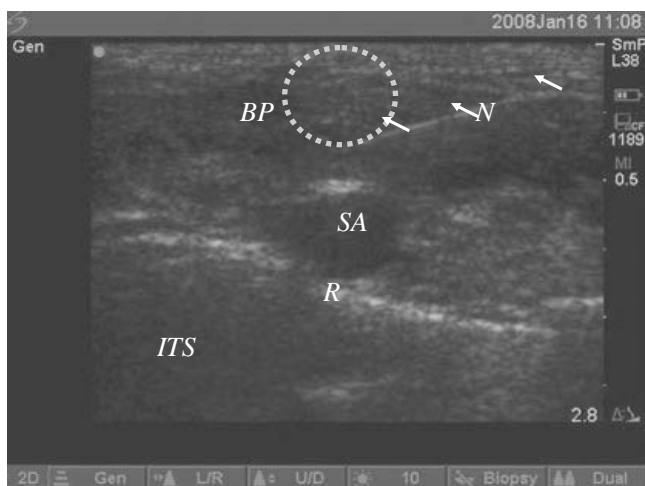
• Ultrasound-Guided Supraclavicular Brachial Plexus Block. Image showing the performance of a supraclavicular brachial plexus block, with needle visible in the long axis of the ultrasound beam. SA, subclavian artery; R, first rib; BP, brachial plexus (resembles a bunch of grapes); N, needle; ITS, intra-thoracic space.
